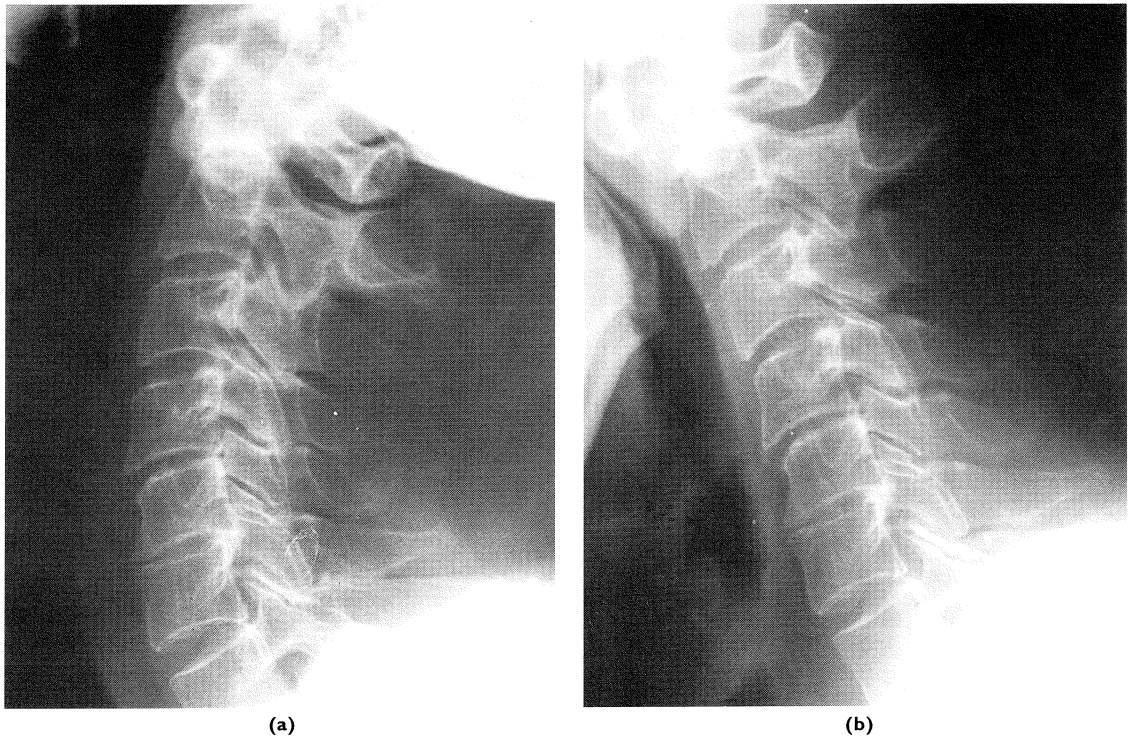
Lateral radiographs of the cervical spine taken in (a) extension and (b) flexion
